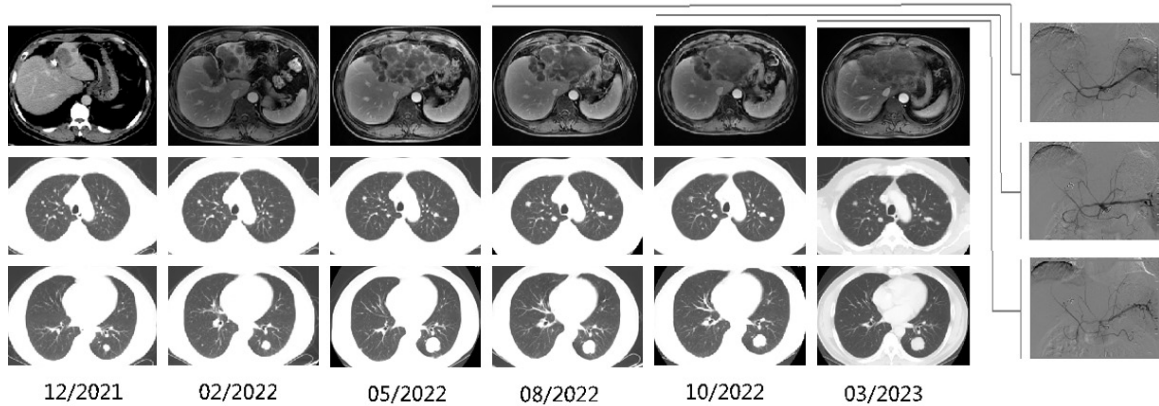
Representative images over the course of therapy. MRI imaging in the first row and CT imaging in the second and third rows showed a continued progression of the left liver lesions and the metastases in both lungs after three cycles of fruquintinib plus tislelizumab and two cycles of regorafenib plus raltitrexed and oxaliplatin chemotherapy from December 2021 to May 2022, followed by a durable stable disease under eleven cycles of TAS-102 in combination with fifteen cycles of bevacizumab and three TACEs in salvage-line treatment from May 2022 to April 2023. The pictures on the right demonstrated the hepatic arteriography of the three irinotecan-TACE procedures in sequence.
